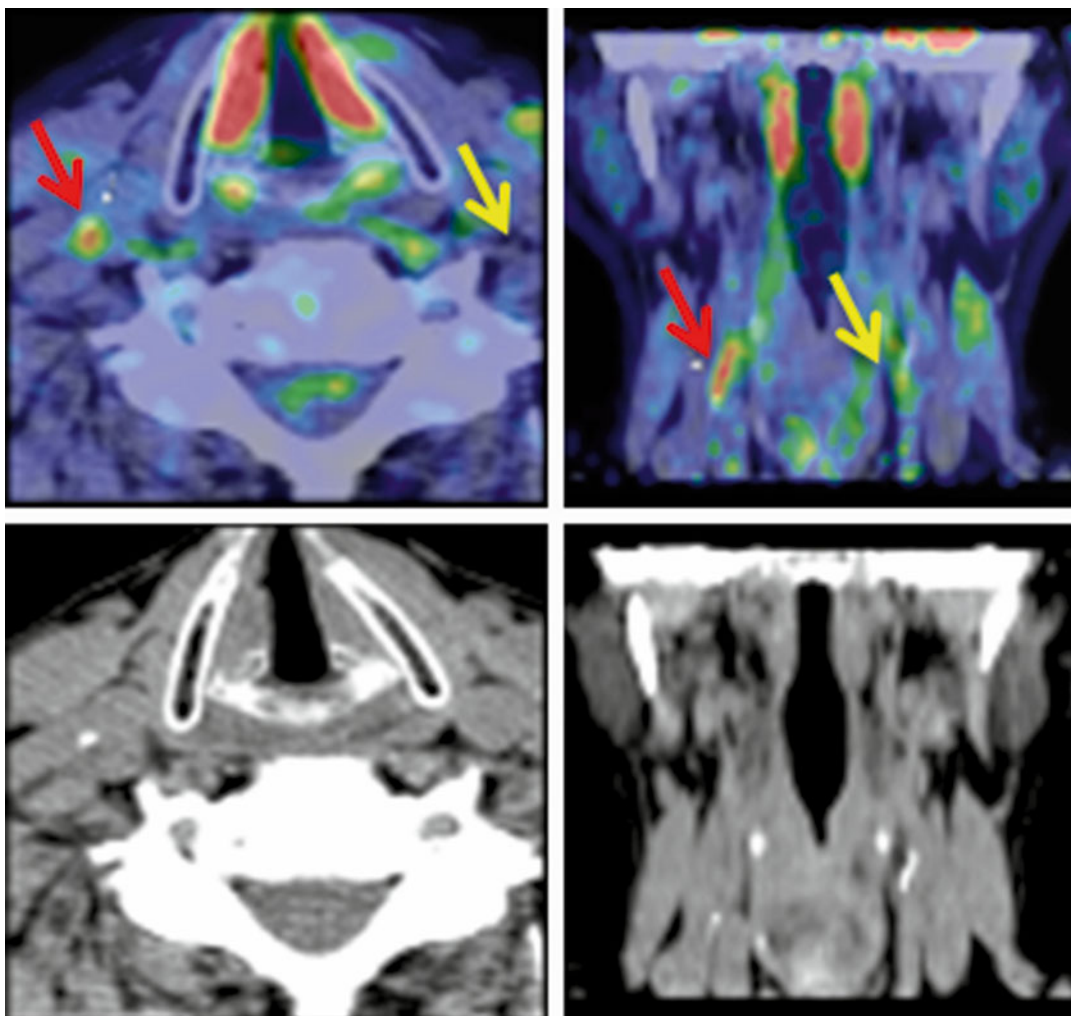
[^{18}F]-FDG PET/CT carotid artery imaging. Transversal and coronal images display a vulnerable carotid plaque on the *right side* with intense tracer uptake.
